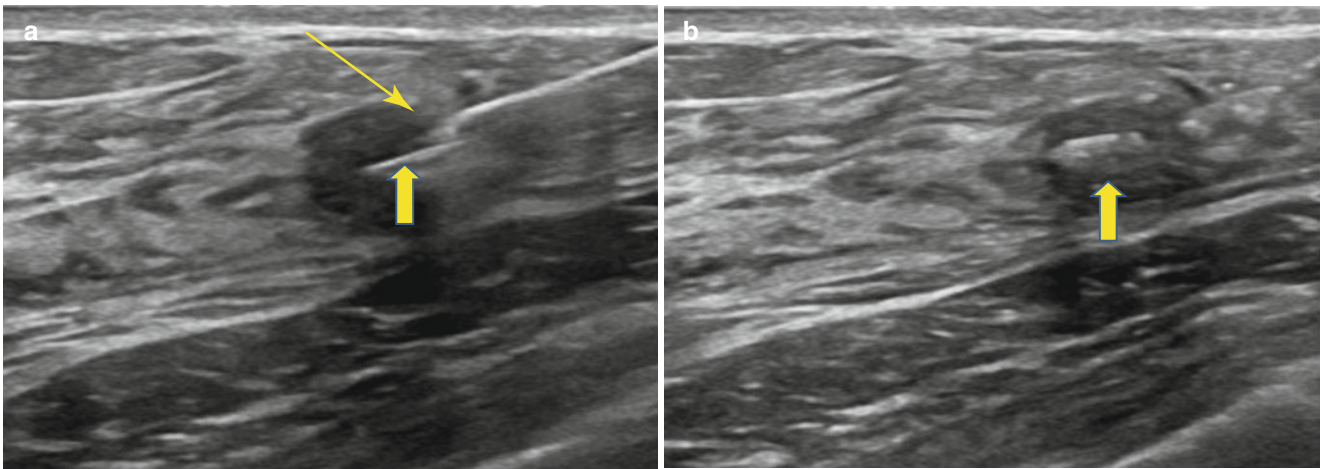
(a, b) Clip deployment. (a) The breast tissue marker needle tip is inserted into the mass under direct ultrasound visualization. Clip (*thick arrow*) is deployed from the tip (*thin arrow*) or distal side port.
